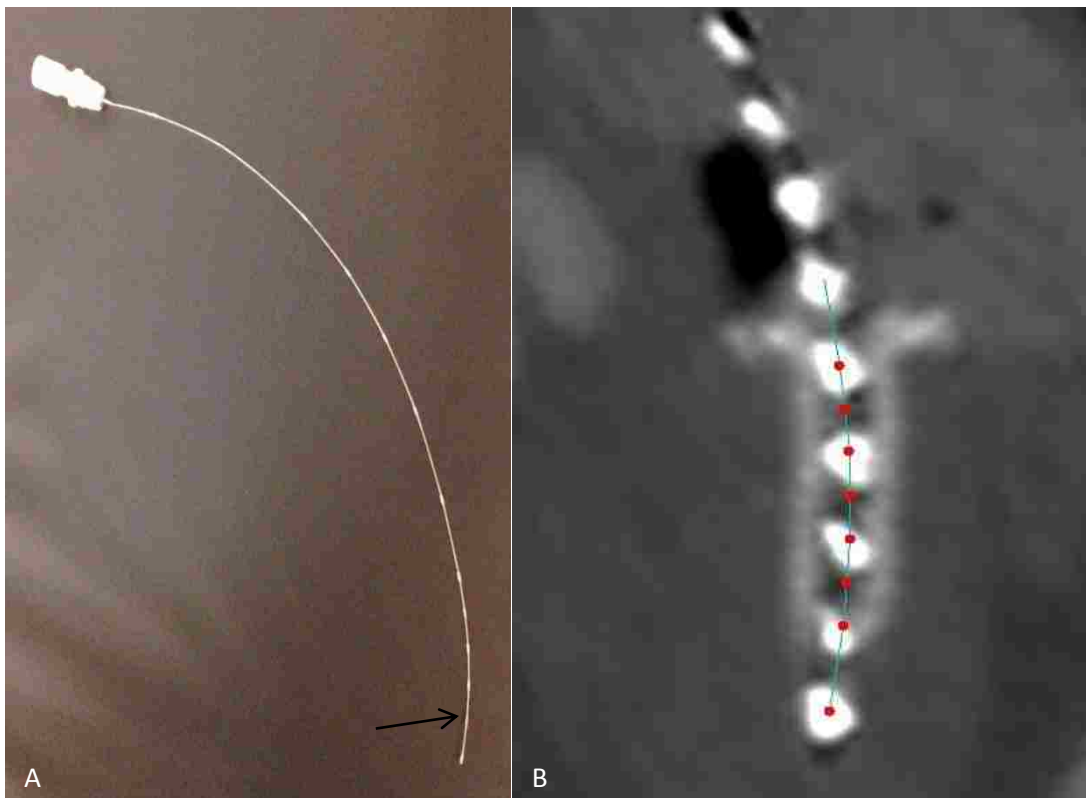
CTMR applicator source position markers. (A) Metallic markers along wire strand (a single marker pointed out by black arrow) representing various source positions within the catheter. (B) Sagittal CT slice showing the source position markers (white marks) and planned TPS dwell positions (red dots along green reconstructed catheter).
